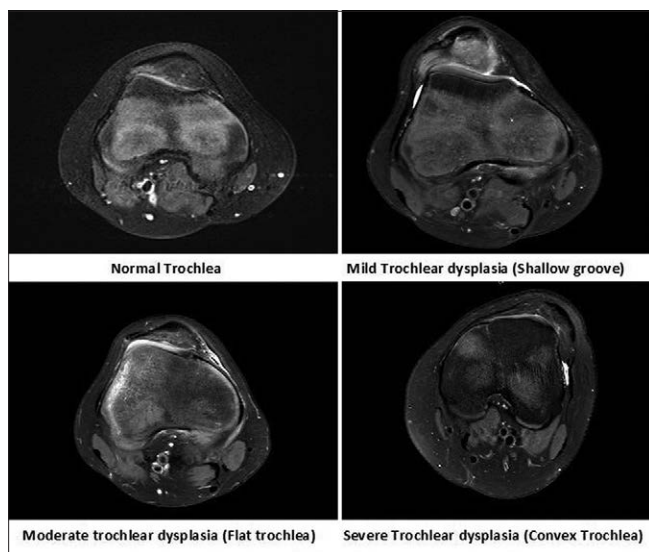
Oswestry-Bristol classification representative axial magnetic resonance imaging images with 100% agreement among all seven observers
